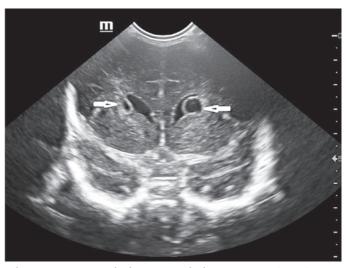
Coronal view cranial sonography shows thin walled cysts (arrows) in the superior and lateral aspect of frontal horns of lateral ventricle
